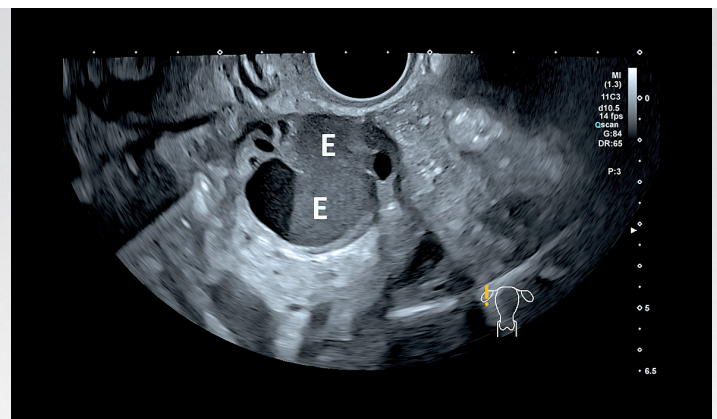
Serial 2D imaging of the same endometriotic cyst (E) showing changes in ultrasound appearances at pre-menses [a], menses [b] and post-menses stages.
